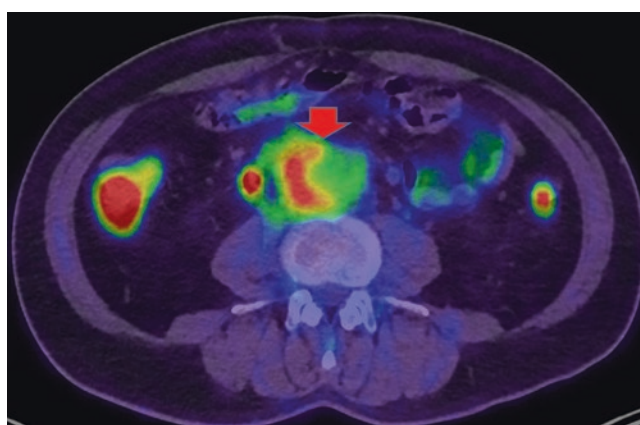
FDG-PET/CT axial image during follow-up
